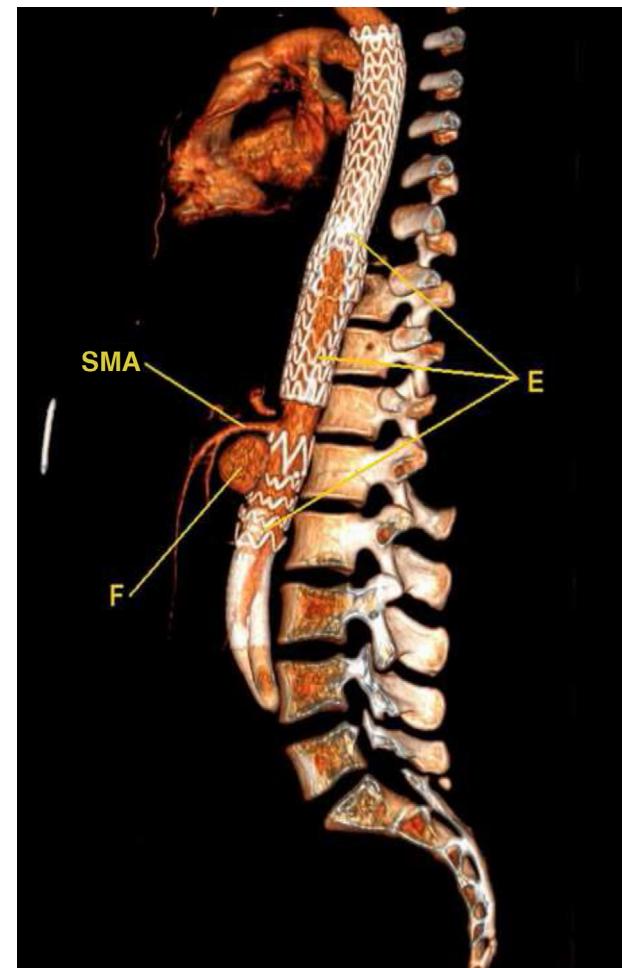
3D reconstruction of a CT angiogram showing 2 overlapping stents (E) in the proximal descending aorta and another bifurcated stent in the abdominal portion of the aorta. Immediately caudal to the origin of the superior mesenteric artery (SMA), a type I endoleak is observed (F).
